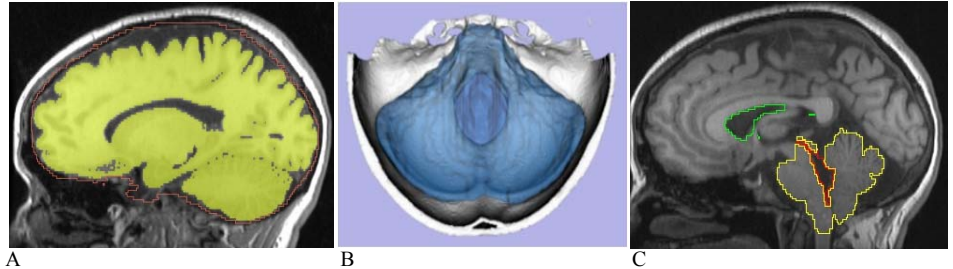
The segmented brain tissue (shaded-yellow) and intracranial (orange) masks overlaid on T1-weighted image (A), the 3D rendered PCF mask from MNI 152 reference data displayed on the MRI rendered skull model (B), and the fourth (red) and lateral (green) ventricles and the hindbrain (yellow) delineated by FreeSurfer overlaid on a sagittal T1-weighted image (C).
